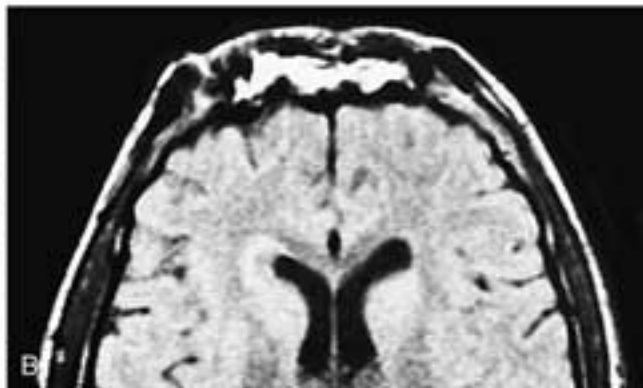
Sagittal T1-weighted (A) and axial proton density (B) MR images show high signal intensity material (fat) within the obliterated sinus. The bone flap, which is often hard to identify on MR images, is in a good position.
